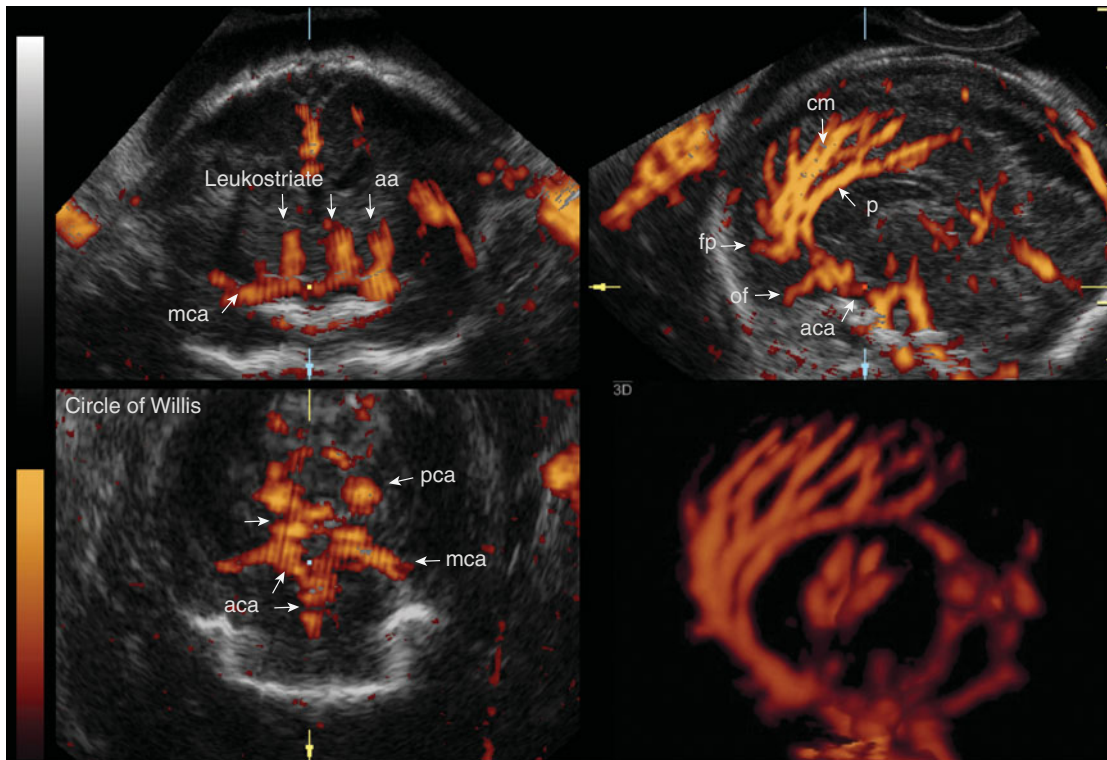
3D angiography display mode enables selective imaging of blood flow through vessels after a 3D acquisition of a volume with power Doppler. The anterior cerebral artery (acm), callosomarginal artery (cm), the pericallosal artery (p), orbitofrontal (of), fronto polar artery (fp), middle cerebral artery (mca), posterior cerebral artery (pca), and posterior communicating artery (Post Com) are presented.
